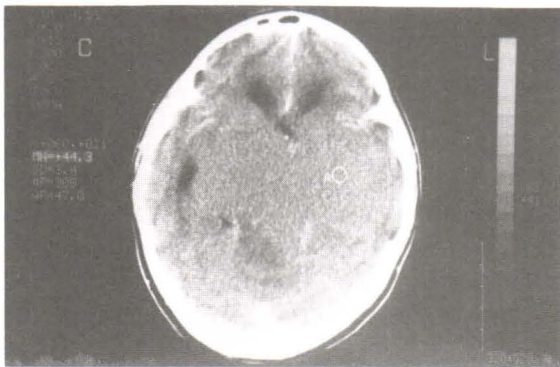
At diagnosis a brain CT scan : showing a large isodensity mass 9 x 5 x 4 cm in size obliterates the suprasellar cistern.
